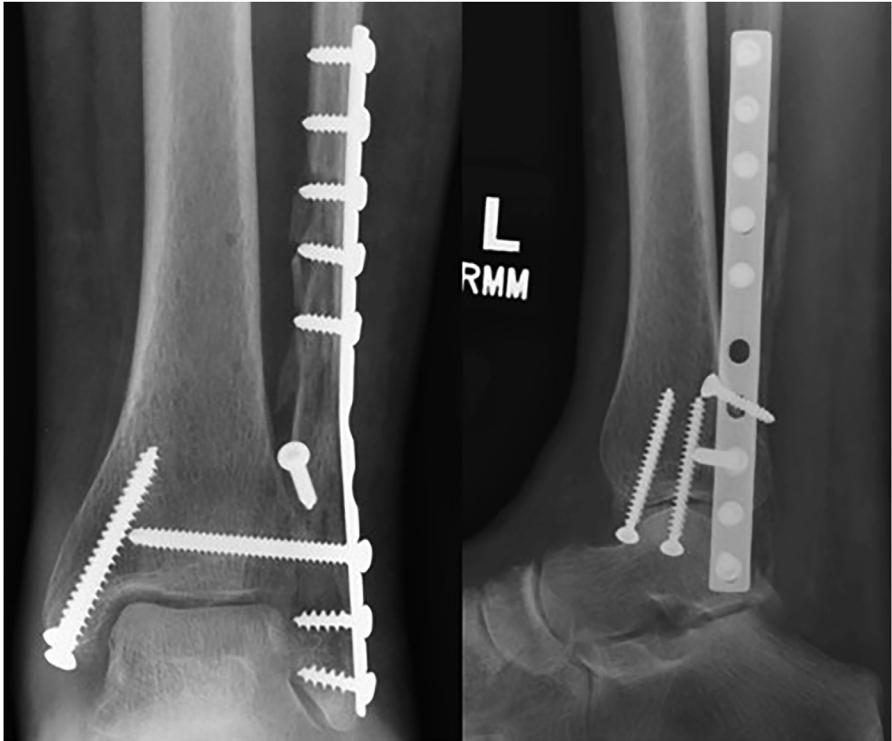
Postoperative radiographs of the same patient 2 months later. The patient walked in a short leg cast immediately after surgery. The mortise remained intact. Note fibula callus formation.
